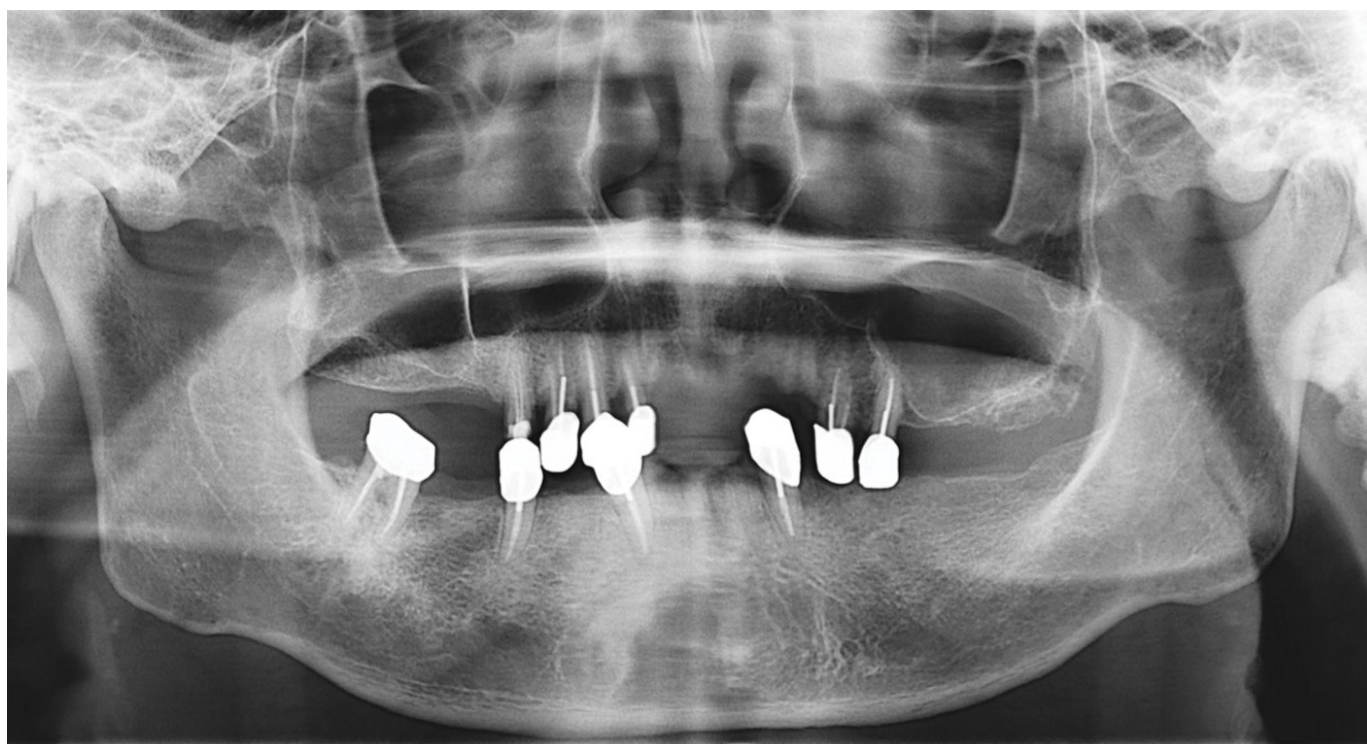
The panoramic radiograph film taken after three months of follow-up.
